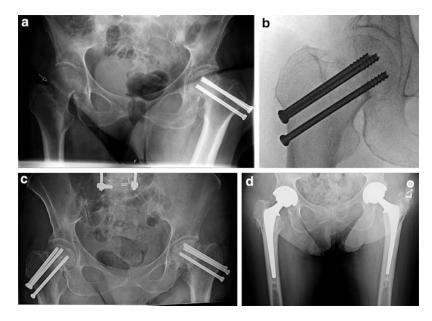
Vignette 4 - failed screw fixation. (a) This AP radiograph shows an acute femoral neck fracture on the right hip. The arrow points to an impacted minimally displaced fracture. The left hip has cannulated screw fixation from previous fracture with a healed shortened fracture. (b) Intraoperative fluoroscopy shows the fracture fixation with three cannulated screws in good position.
